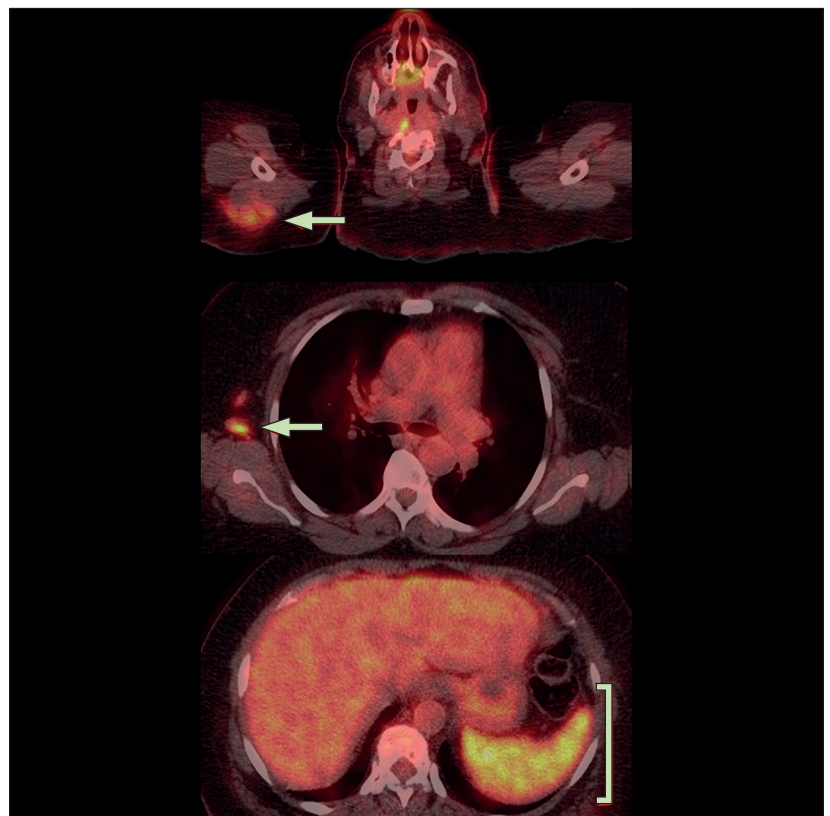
¹⁸F-fluorodeoxyglucose PET/CT findings in a systemic inflammatory response syndrome after COVID-19 vaccine
